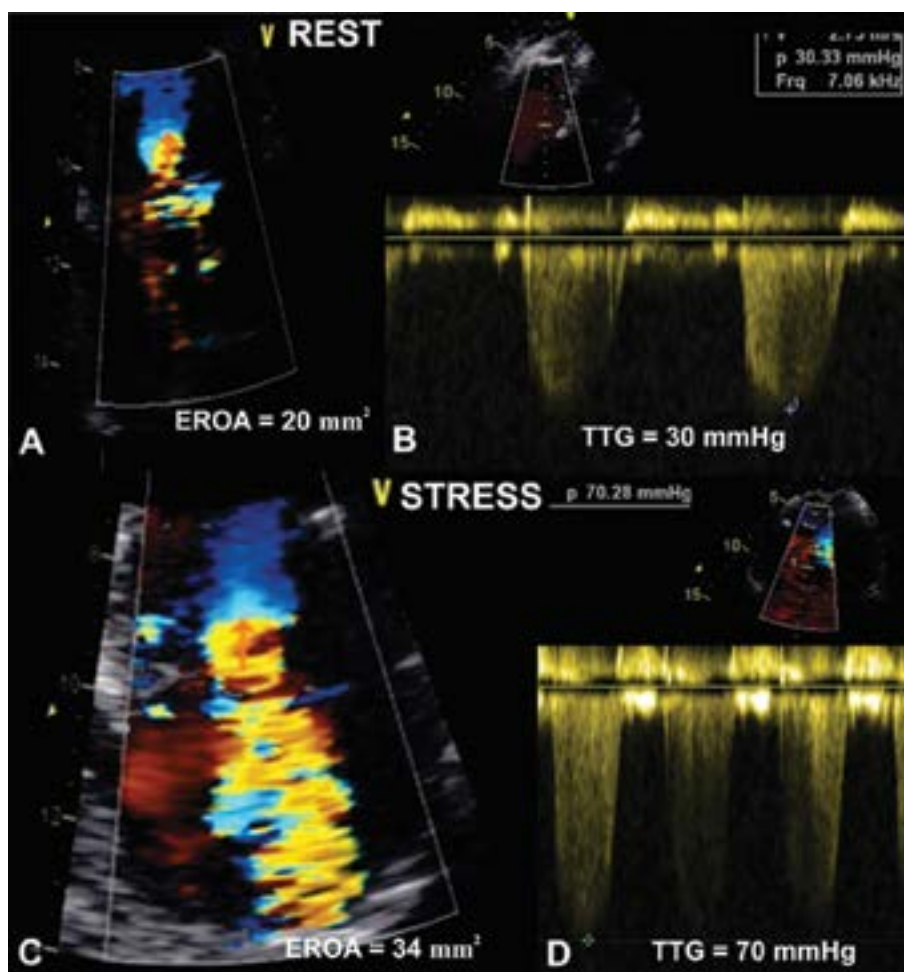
Doppler findings in a symptomatic patient with moderate primary MR and borderline SPAP at rest (upper panels). During EE, a marked increase in MR associated with pulmonary hypertension (lower panels) and exercise-induced symptoms was observed. The patient underwent MV repair; EROA – effective regurgitant orifice area; TTG – trans-tricuspid gradient
